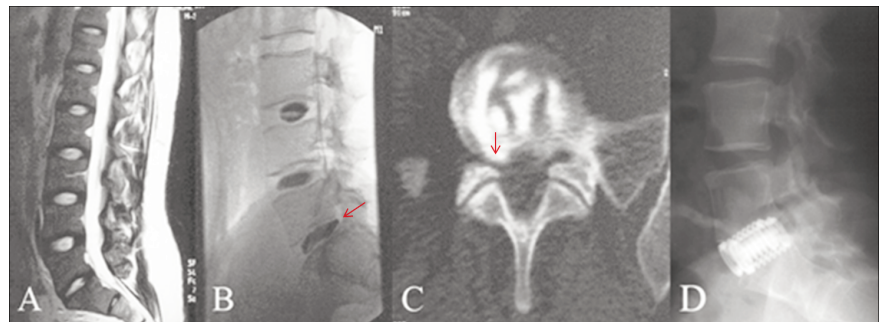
A) Sagittal T2-weighted magnetic resonance imaging showing loss of lumbar lordosis; B) discography showing an annulus fibrosus tear of the L5-S1 disc; C) computed tomography discography showing contrast material in the spinal canal (note the annulus tear near the right foramen of the foraminal location); D) a postoperative lateral lumbar radiograph of the patient.
